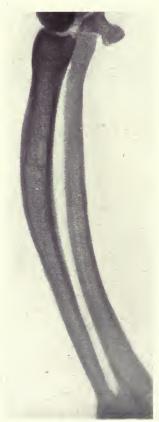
Exp. 192. Radiograph 6 months after alteration back to defective diet. Linseed oil in place of cod-liver oil. For previous diets see notes, Figs. 97 and 96. No evidence of further rickets. Note thin periosteal bone and thick marrow cavity as compared with Exp. 198, Fig. 91.
